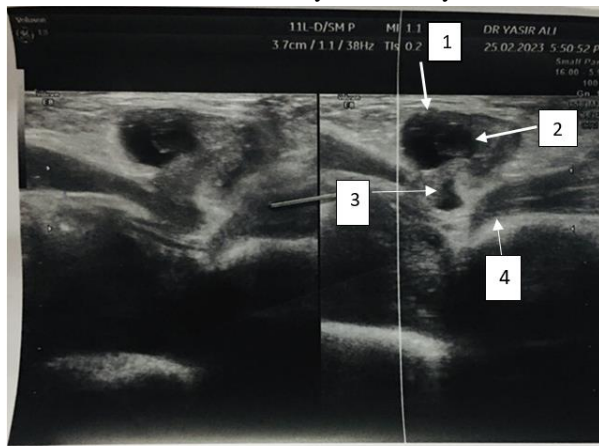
Shows ultrasound of the patient
